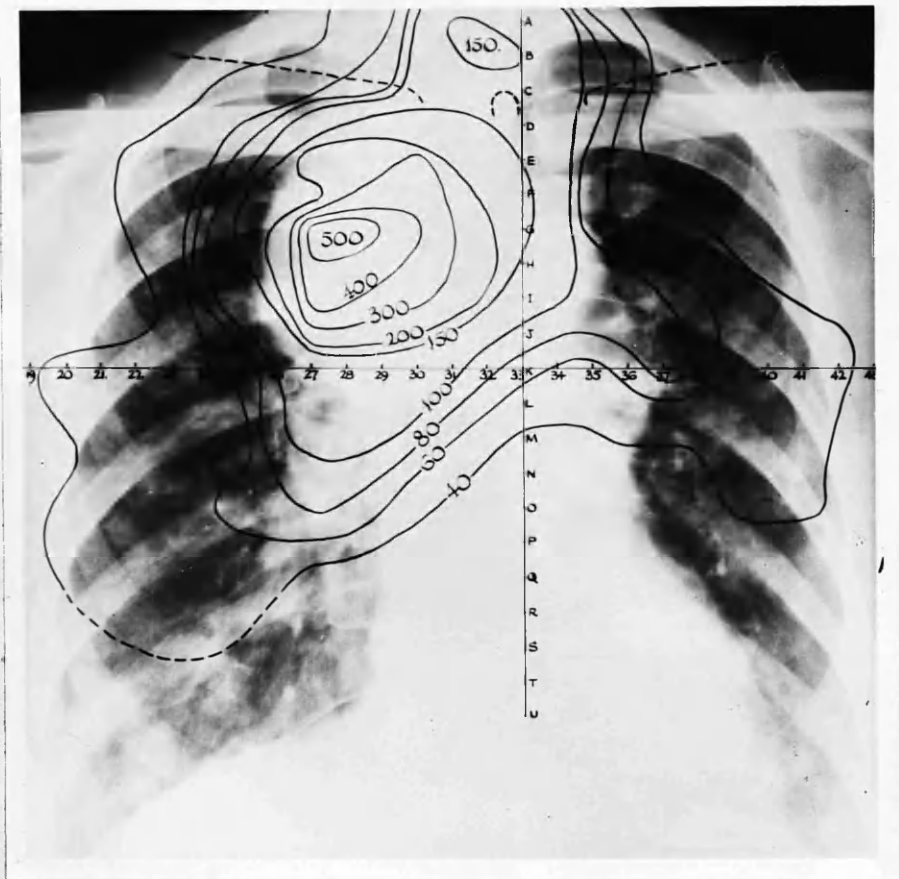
Radiograph of chest of Case Mrs. N.B. showing mediastinal secondary with metastatic deposits in lung fields. Superimposed on the X-ray are the lines of equal counting rate from radioactive iodine. Note the coincidence of the lines representing greater activity with the shadows of the metastases.
